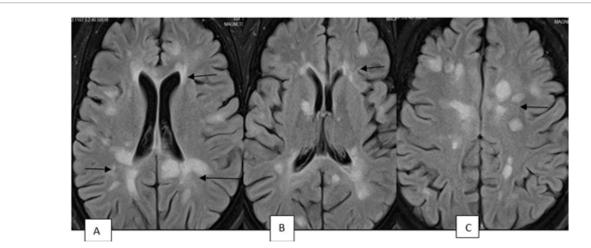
IRM sequence FLAIR. Numerous widely distributed intense periventricular subcortical signals. Leave out the stuff bout perpendiculars.
